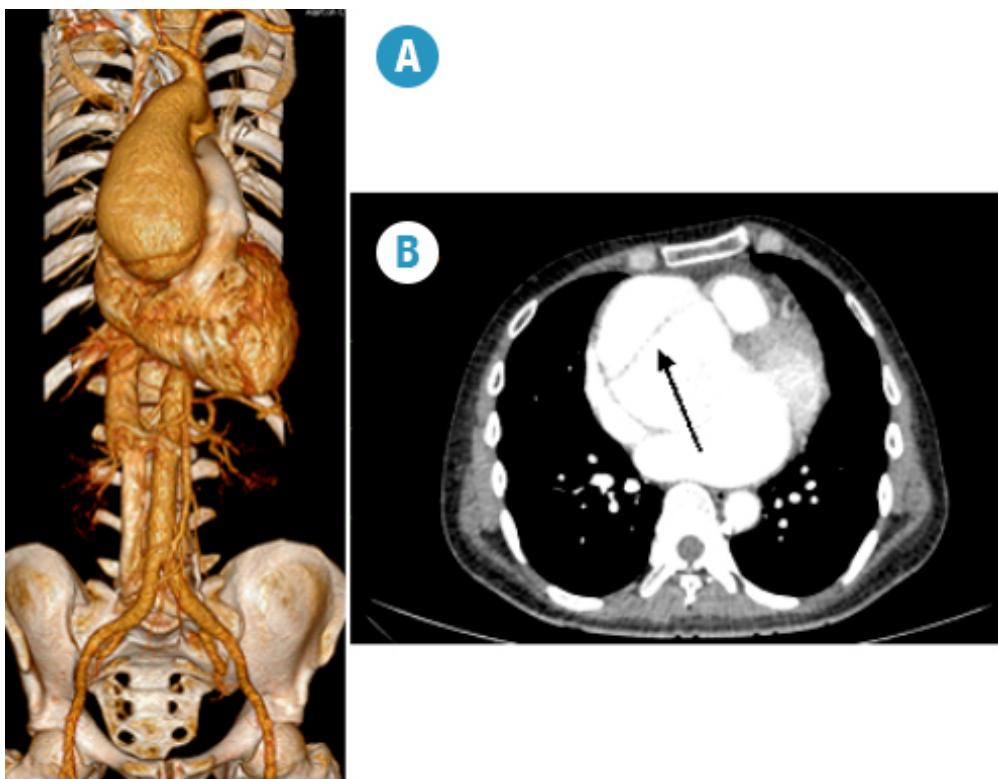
3D reconstruction of computed tomography angiography of the chest. Dilation of the ascending aorta. Aortic root 90.2 mm, anteroposterior diameter of ascending aorta of 80.8 mm.
